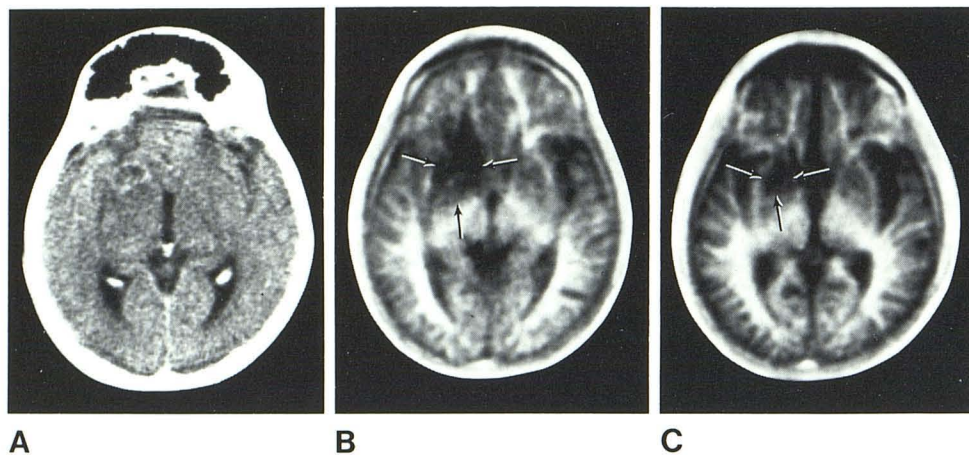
Tuberculous abscess. A, Contrast-enhanced CT. B, IR_{1400/400}. C, Follow-up IR_{1400/400} 7 months later. Abnormal area has long T₁ and is smaller on follow-up scan (arrows).
